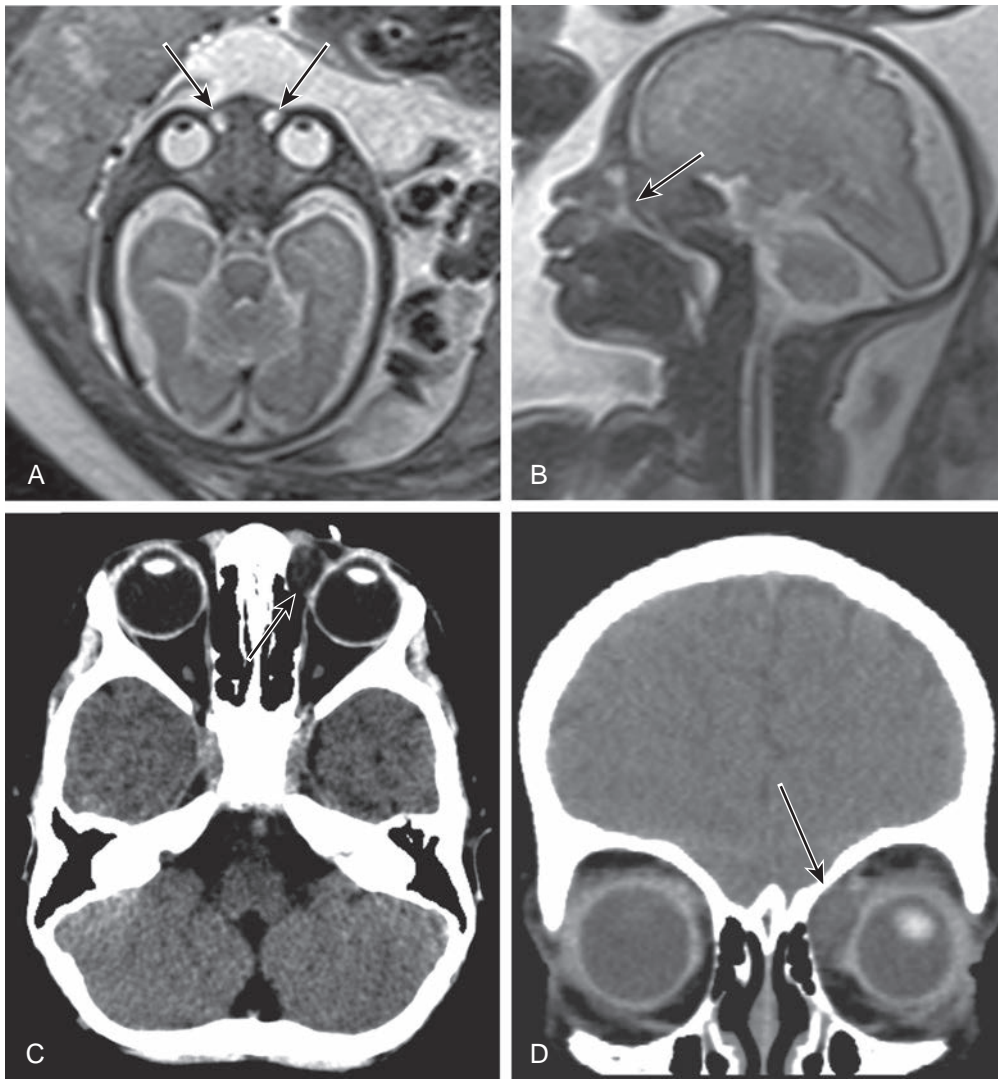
Dacryocystocele. (A) Axial fetal MRI shows bilateral cysts in the medial canthi (arrows). (B) Sagittal fetal MRI showing a dilated nasolacrimal duct (arrow). (C) Axial noncontrast CT shows a well-circumscribed low attenuation in the region of the left nasolacrimal duct (arrow). (D) Coronal CT shows a left dacryocystocele (arrow).
